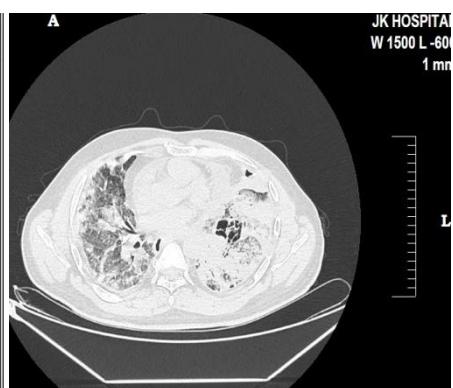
HRCT of young patient age between 41-45 year showing multiple discrete and confluent patches of GGO with cavitory consolidation and septal thickening CT severity score; 32-34 (Severe lung involvement).
